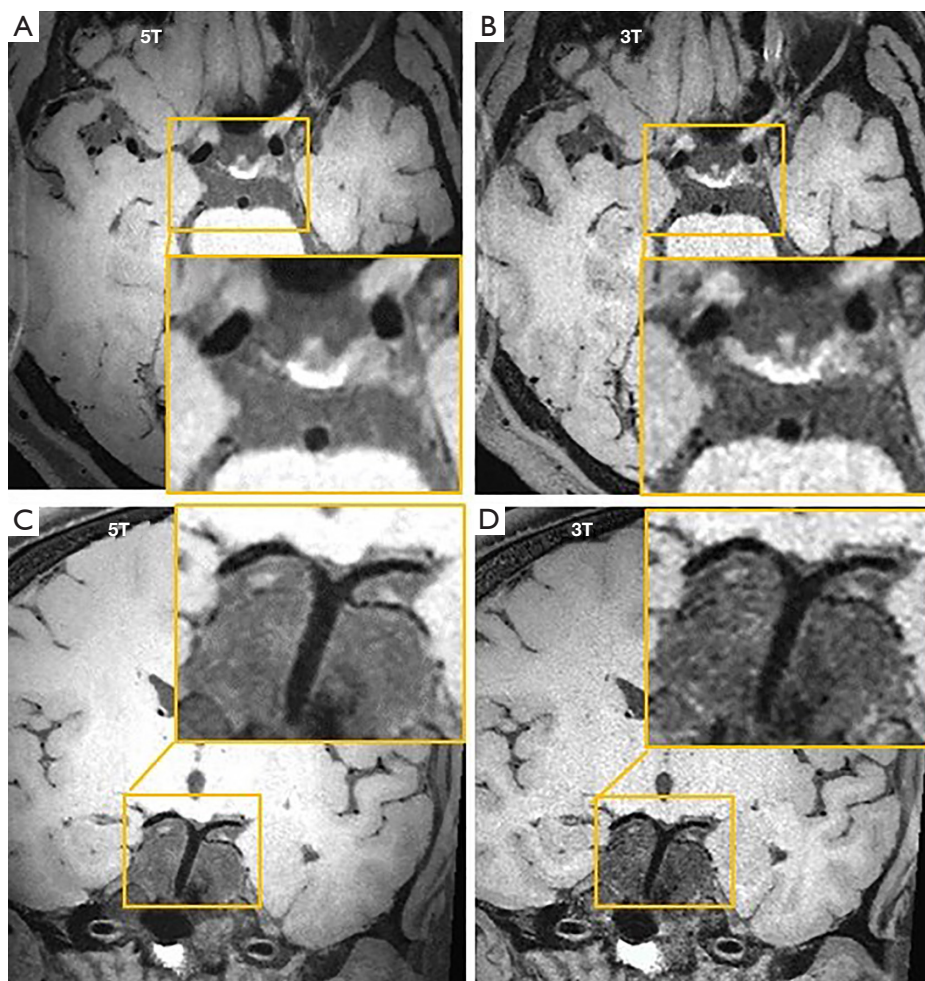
Vascular wall images of basilar arteries obtained by a T1-weighted three-dimensional MATRIX sequence from a healthy volunteer (39 years old; male; 170 cm; 80 kg). The images were obtained with a $0.5 \text{ mm} \times 0.5 \text{ mm} \times 0.5 \text{ mm}$ reconstructed resolution for 5T (A,C) and 3T (B,D). Magnification of areas in the brain (yellow rectangles) at 5T and 3T are also displayed. MATRIX, Modulated flip Angle Technique in Refocused Imaging with eXtended echo train.
